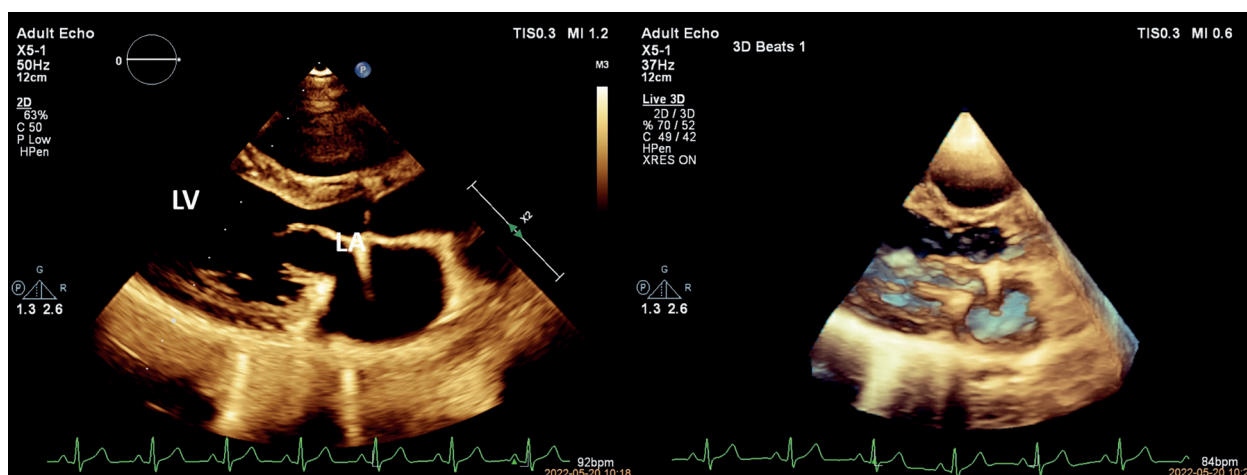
Image after mitral valve reconstruction. Two-dimensional echocardiography (left) and three-dimensional echocardiography (right) in the parasternal projection along the long axis of the left ventricle. Left ventricular diastolic phase. Valve leaflets open wide and flow freely into the left ventricle (LV). Enlarged left atrium (LA)
